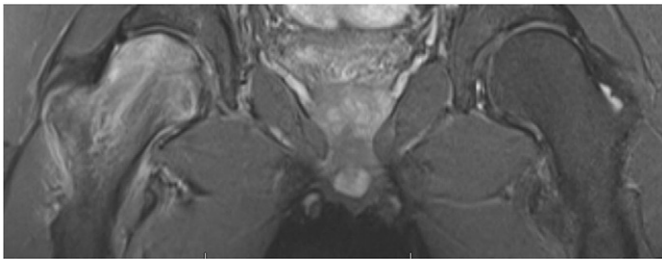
MRI of right hip revealing diffuse bone marrow edema.
